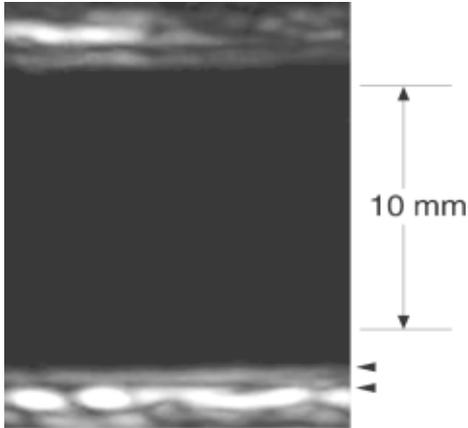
Ultrasonic image of the abdominal aorta imaged with a 5 MHz transducer. Upper arrowhead, luminal-intimal interface of the aortic wall; lower arrowhead, corresponding medial-adventitial interface. Intima-media thickness was defined as measured distance between these interfaces.
